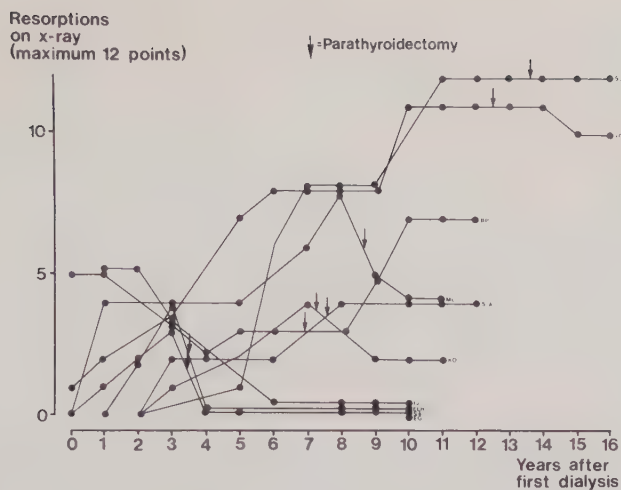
The course of resorption on X-ray in 10 patients dialyzed for 10 years or more. Maximum 12 points. ↓ denotes parathyroidectomy.
